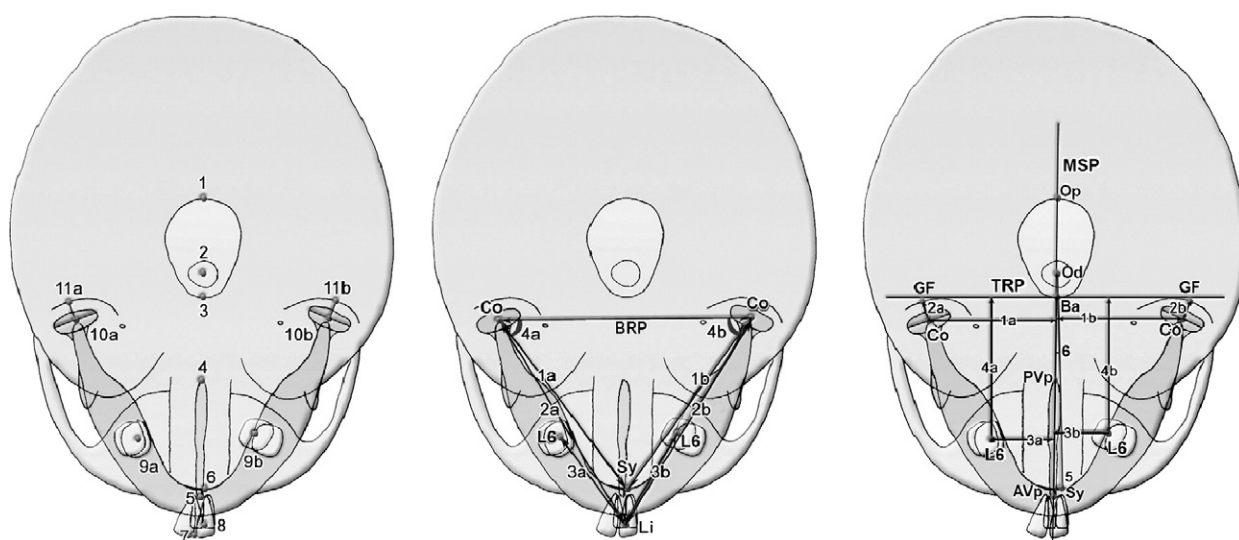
A, Landmarks used in submentovertex cephalometric radiographs (a, right side; b, left side): 1, opisthion (Op); 2, odontoid process (Od); 3, basion (Ba); 4, posterior vomer point (PVp); 5, anterior vomer point (AVp); 6, symphyseal point (Sy); 7, upper 1 (U1); 8, lower 1 (L1); 9, lower 6 (L6); 10, condylion (Co); 11, glenoid fossa (GF). B, Morphological measurements of mandible in submentovertex radiographs: 1, condylion-symphysis distance (Co-Sy); 2, condylion-mandibular midline distance (Co-L1); 3, mandibular first molar-mandibular midline distance (L6-L1); 4, bicondylar reference plane-condylion-symphysis angle (BRP-Co-Sy). C, Positional measurements of mandible in submentovertex radiographs: 1, condylion-midsagittal plane distance (Co-MSP); 2, condylion-glenoid fossa distance (Co-GF); 3, mandibular molar-transverse reference plane distance (L6-TRD); 4, symphysis-midsagittal plane distance (Sy-MSP); 5, symphysis-basion-midsagittal plane angle (Sy-Ba-MSP).
